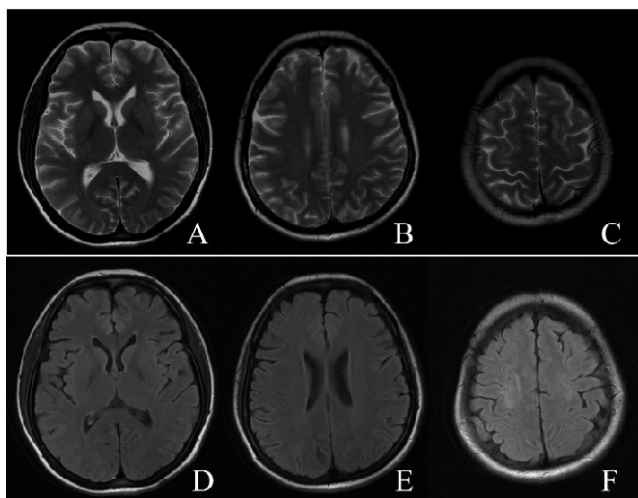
The MR images of the patient after treatment showed the lesions on brain MRI disappeared completely after treatment.
